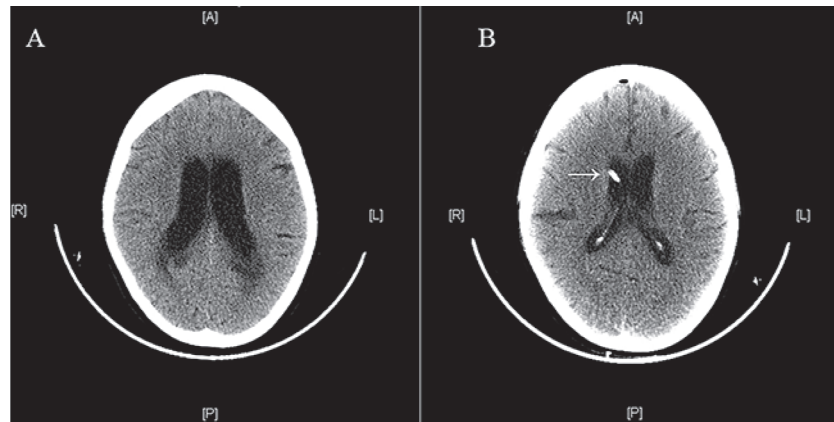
Plain computed tomography of the brain showed moderate communicating hydrocephalus with periventricular hypodensities suggestive of transependymal CSF seepage. (A) Before and (B) after insertion of ventriculoperitoneal shunt indicated by white arrow.
